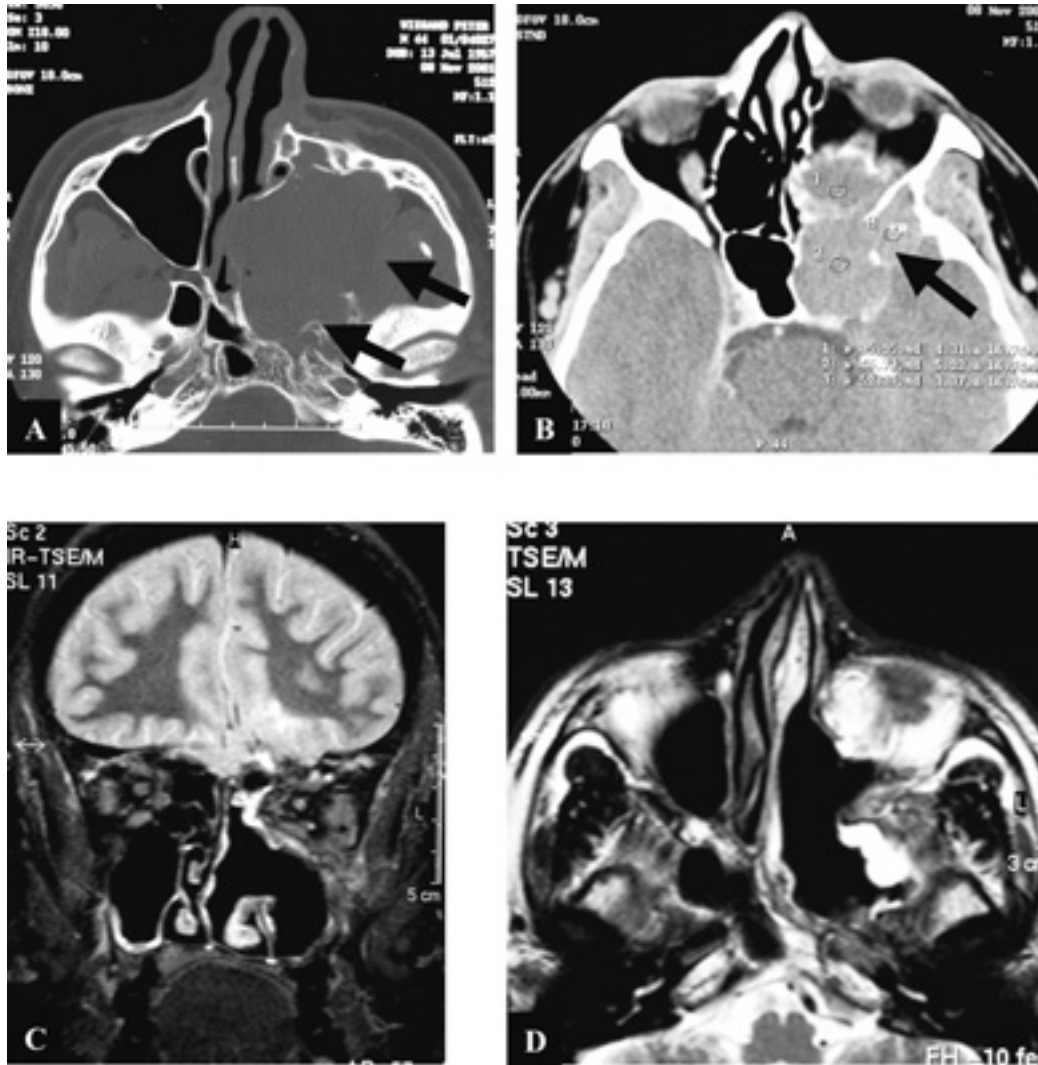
(A) Axial bony window computerized tomography image showing a chambered maxillary sinus mucocoele extend into the infratemporal fossa (arrows). (B) Axial soft tissue window computerized tomography image showing the intracranial mucocoele extension (arrow). (C) T2 weighted coronal and (D) axial magnetic resonance image 4 years after endonasal micro-endoscopic marsupialization of the mucocoele.
